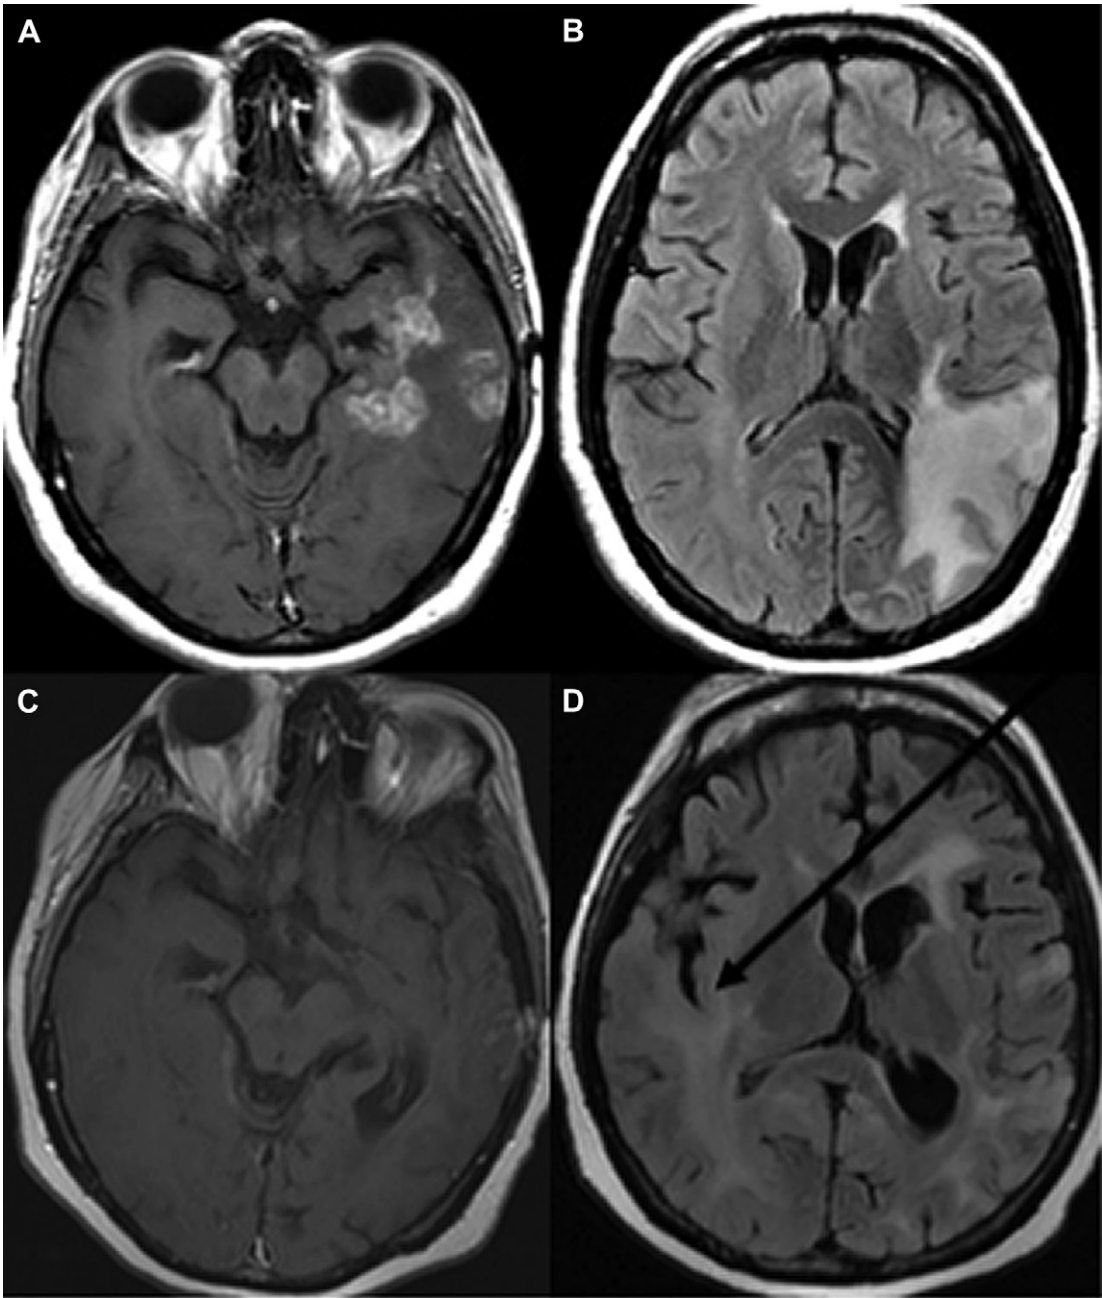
MRI images from a patient with recurrent GBM before and after bevacizumab treatment showing significant radiographic response. Pretreatment axial T1 with contrast (A) and axial FLAIR (fast fluid attenuated inversion recovery) (B). Posttreatment axial T1 with contrast (C) and axial FLAIR (D). Arrow points to interval white matter change that may indicate new tumor.
